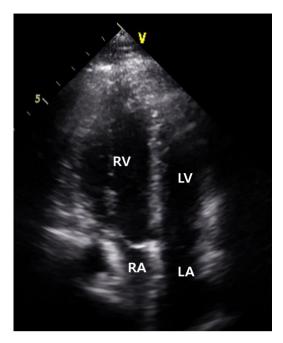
Transthoracic echocardiography showing the compression of right atrium on apical four chamber view. RV, right ventricle; LV, left ventricle; RA, right atrium; LA, left atrium.
